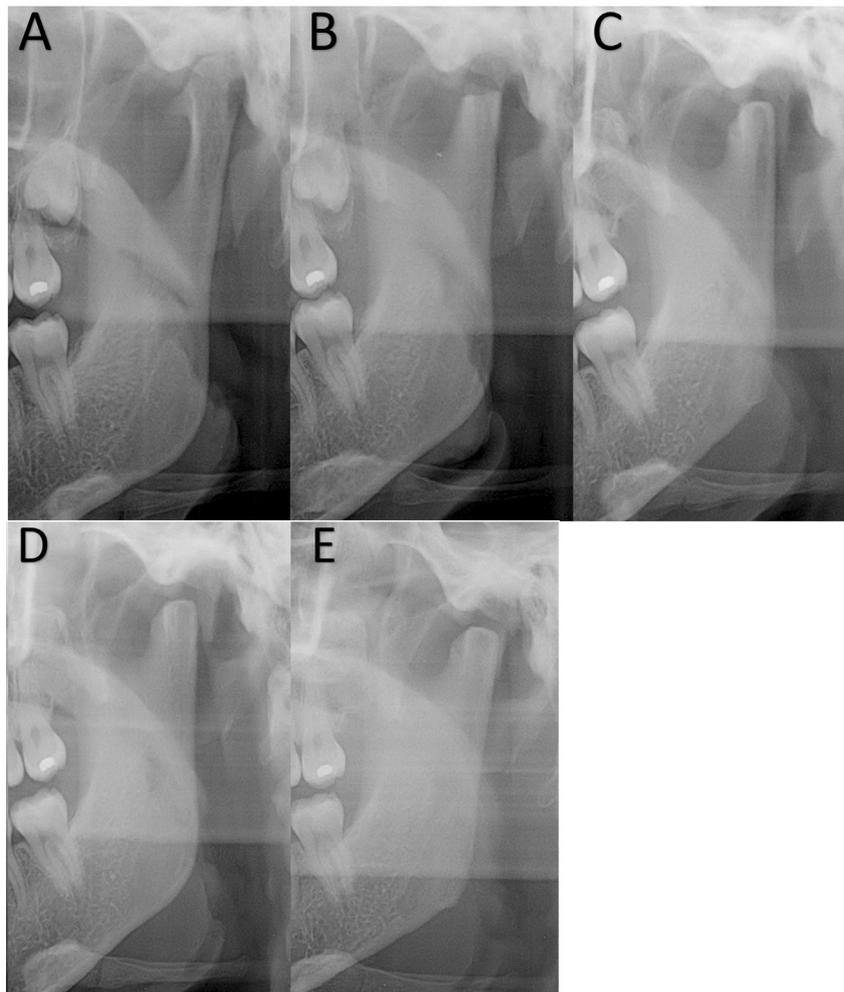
Serial panoramic X-rays after condylectomy showing condyle remodelling to form a neocondyle, which has adapted to the condylar fossa (patient 19): (A) preoperative; (B) immediately postoperative; (C) 2 years postoperative; (D) 4 years postoperative; (E) 6 years postoperative.
